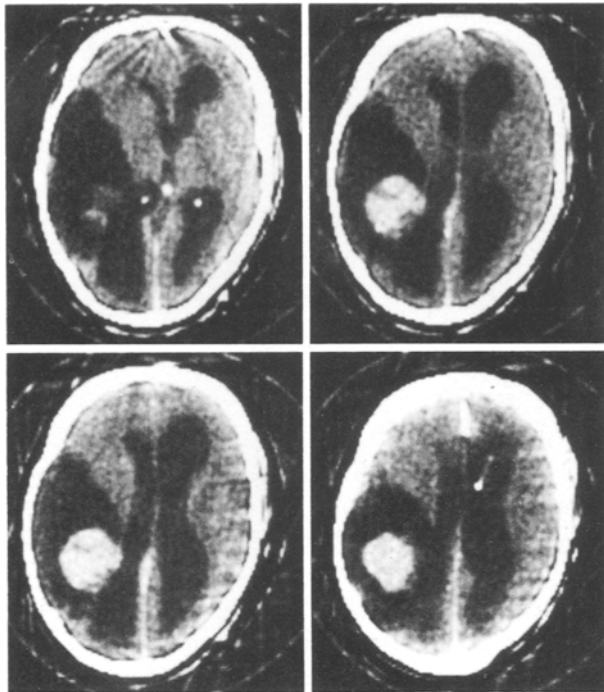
Enhanced CT scan of the same patient showing marked homogeneous enhancement of a trigonal tumour
